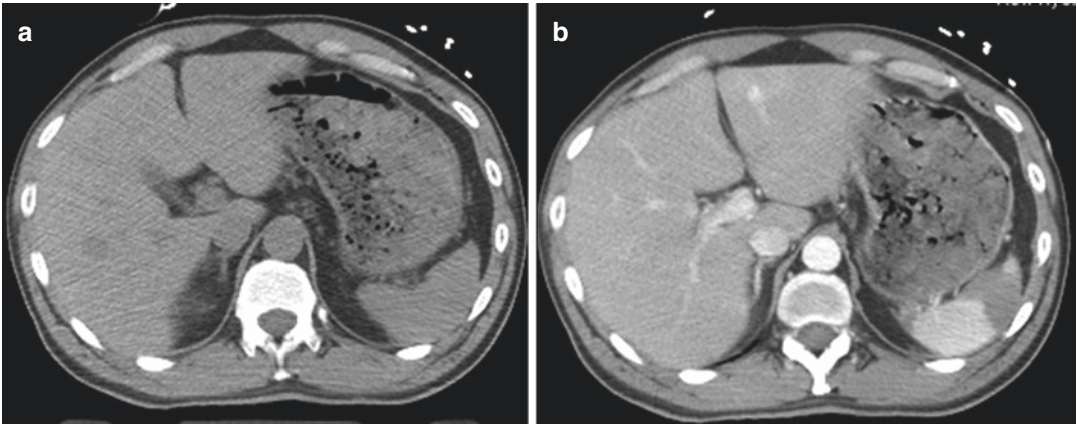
Deep splenic hematoma, not appreciable in nonenhanced CT (a), is well defined in contrast-enhanced CT (b)
